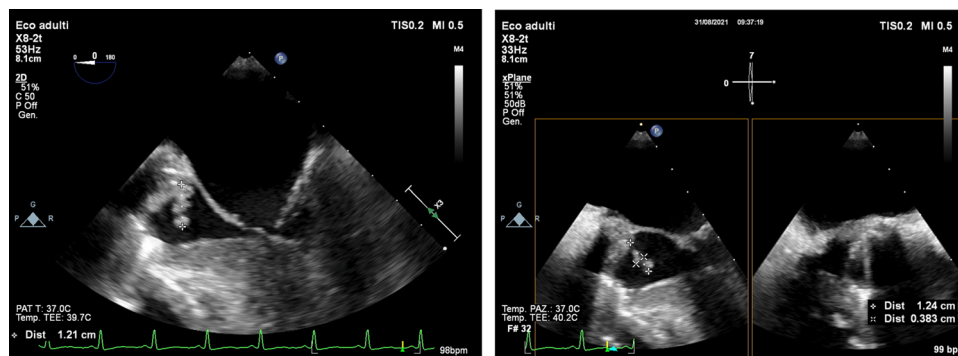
Transesophageal echocardiogram showed pedunculated and mobile vegetations anchored to the aortic annulus and protruding into the outflow tract of the left ventricle.
